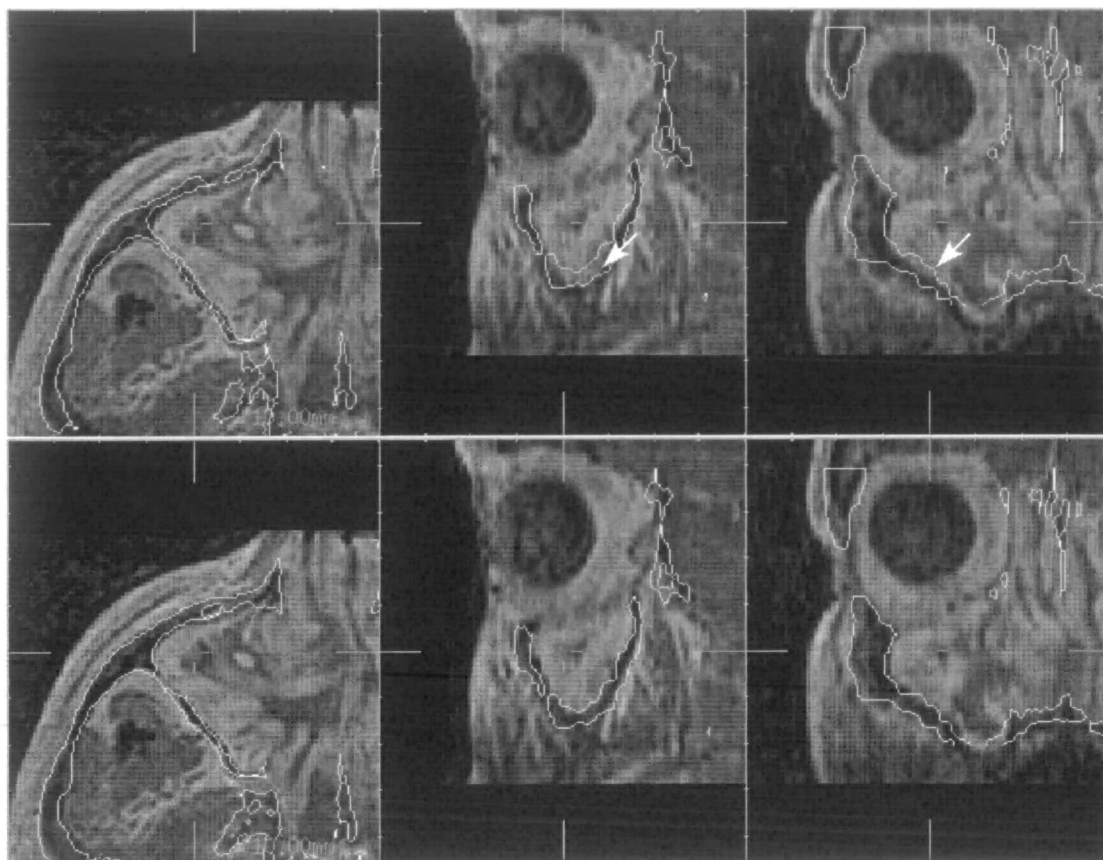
Axial, sagittal and coronal slices through solutions for image pair I: An example where the estimate provided by automated registration (bottom) is visually superior to that provided by manual point based registration (top). White arrows indicate regions of misaligned bone contour from CT.
